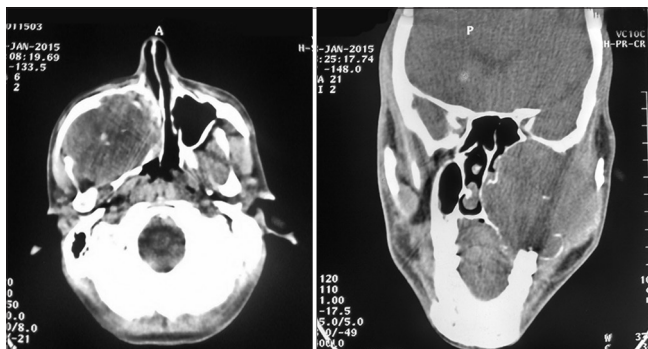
Axial and coronal computed tomography scan
